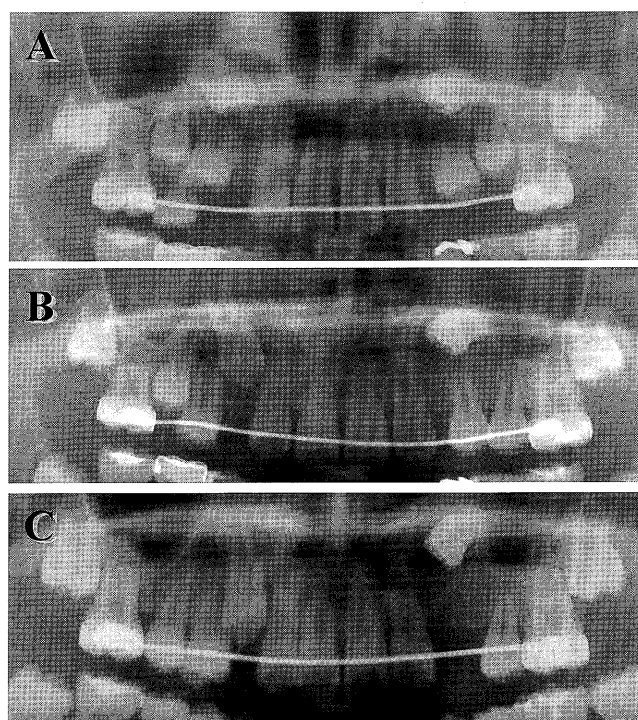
Orthopantomograms at the first fenestration, aged 9 years and 0 months (A), at the second fenestration, aged 10 years and 3 months (B), and at the third fenestration and the start of the traction, aged 11 years and 2 months (C)
